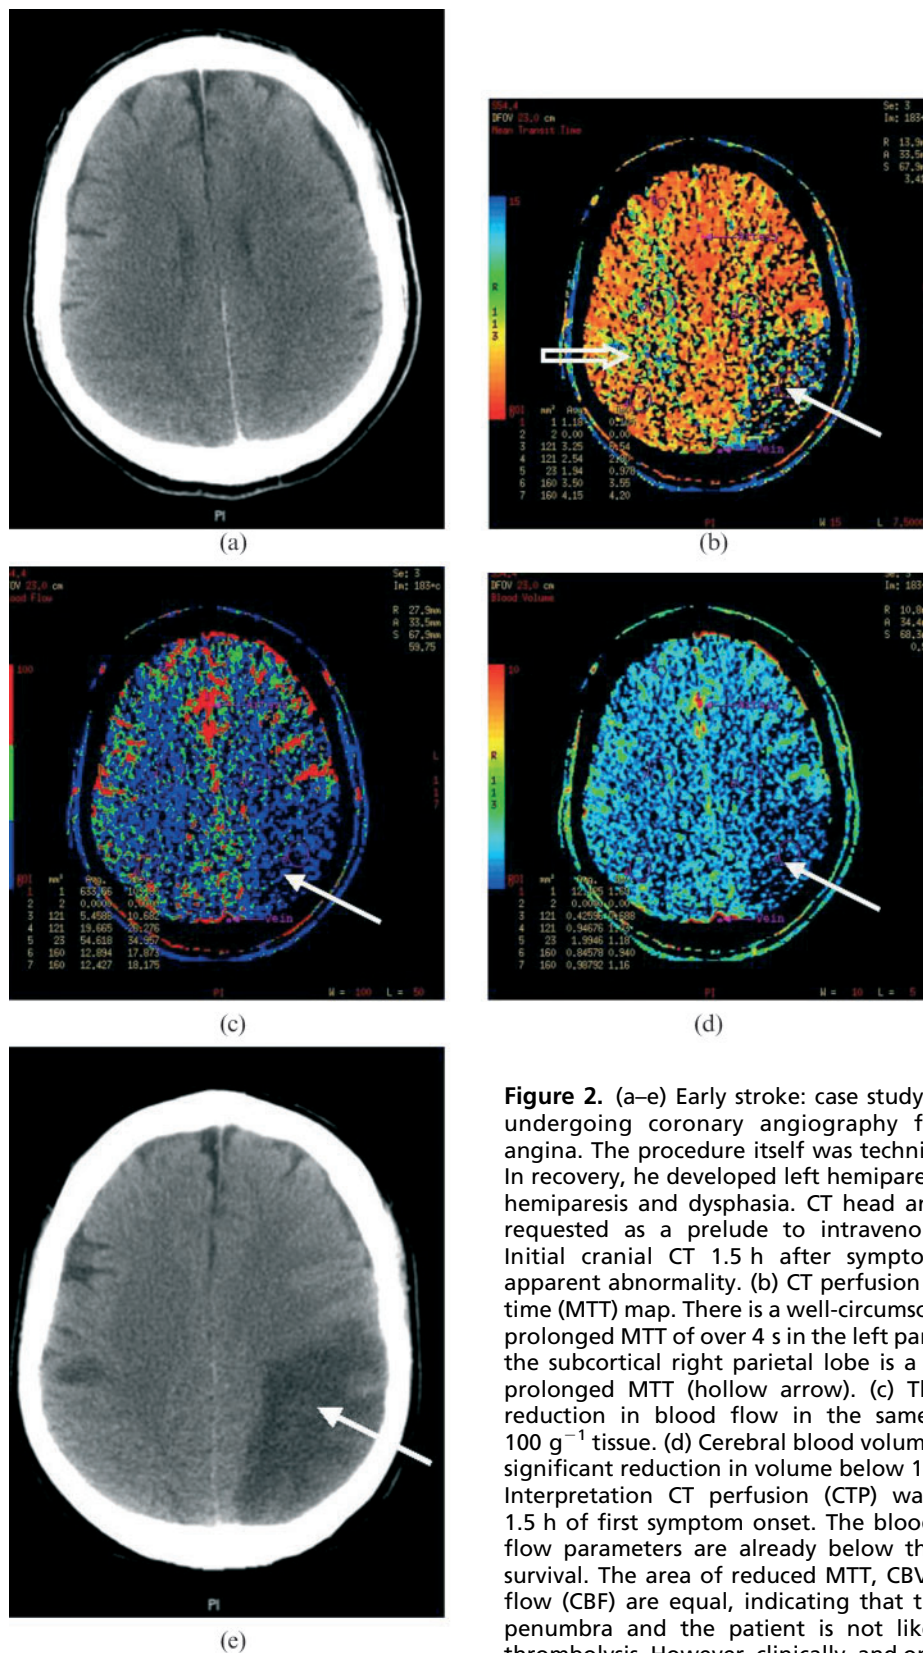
(a–e) Early stroke: case study. A 60-year-old male undergoing coronary angiography for investigation of angina. The procedure itself was technically uncomplicated. In recovery, he developed left hemiparesis followed by right hemiparesis and dysphasia. CT head and CT perfusion was requested as a prelude to intravenous thrombolysis. (a) Initial cranial CT 1.5 h after symptom onset shows no apparent abnormality. (b) CT perfusion image. Mean transit time (MTT) map. There is a well-circumscribed area of slightly prolonged MTT of over 4 s in the left parietal lobe (arrow). In the subcortical right parietal lobe is a more subtle area of prolonged MTT (hollow arrow). (c) There is a significant reduction in blood flow in the same area below 15 ml 100 g⁻¹ tissue. (d) Cerebral blood volume (CBV) map shows a significant reduction in volume below 1.5 ml 100 g⁻¹ min⁻¹. Interpretation CT perfusion (CTP) was performed within 1.5 h of first symptom onset. The blood volume and blood flow parameters are already below the threshold for cell survival. The area of reduced MTT, CBV and cerebral blood flow (CBF) are equal, indicating that there is no ischaemic penumbra and the patient is not likely to benefit from thrombolysis. However, clinically, and on CT criteria (no large established early infarct and no haemorrhage), the patient was suitable for intravenous thrombolysis and this was administered 2.5 h after symptom onset. (e) The patient failed to improve after thrombolysis. Cranial CT performed the following day to exclude haemorrhage shows an infarct that was predicted very accurately by the CTP study. A small contralateral right parietal infarct is also shown.
